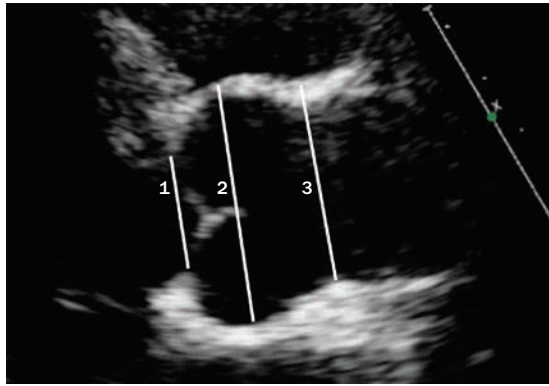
Echocardiography of the aortic root. Components analyzed during assessment of aortic root dilatation are the aortic annulus (1), the sinuses of Valsalva (2), and the sinotubular junction (3). The tubular portion of the ascending aorta should also be assessed.
